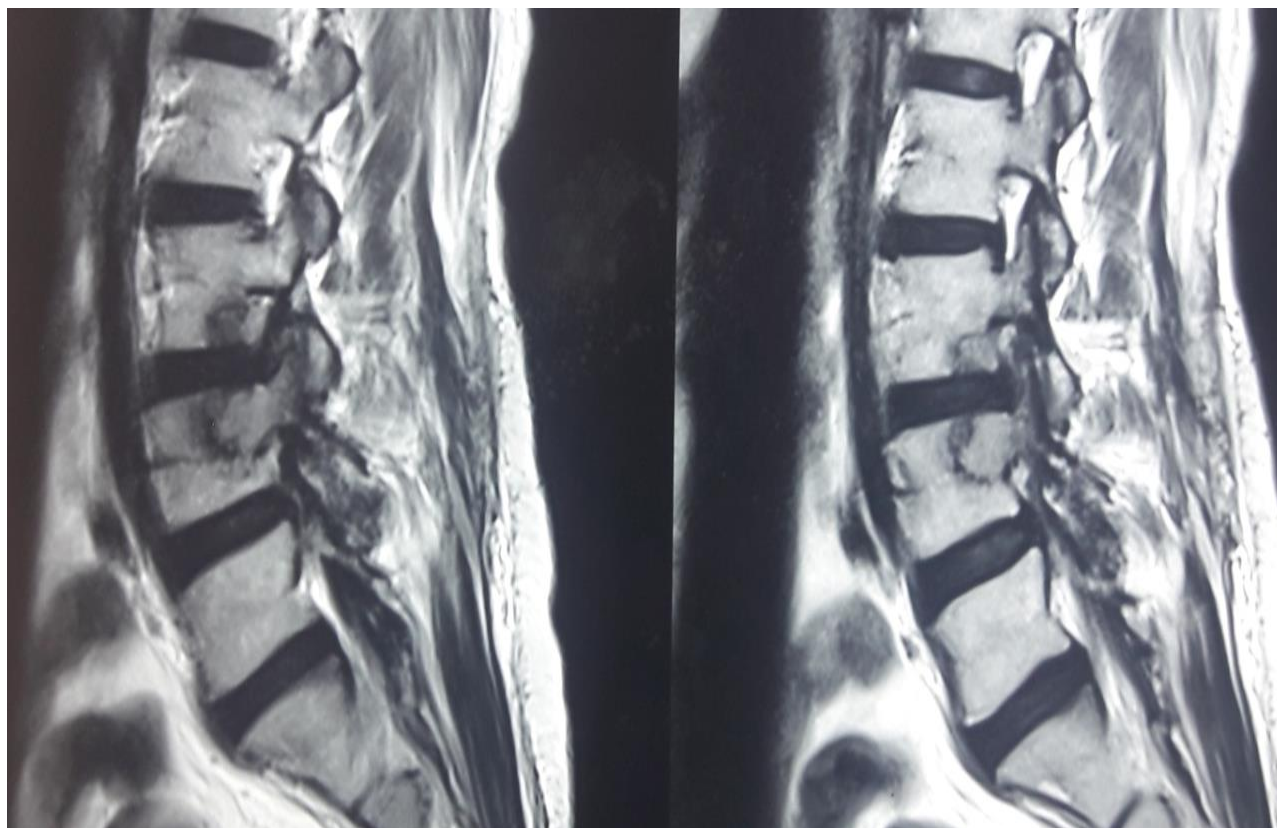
MRI dorsal spine sagittal view.
